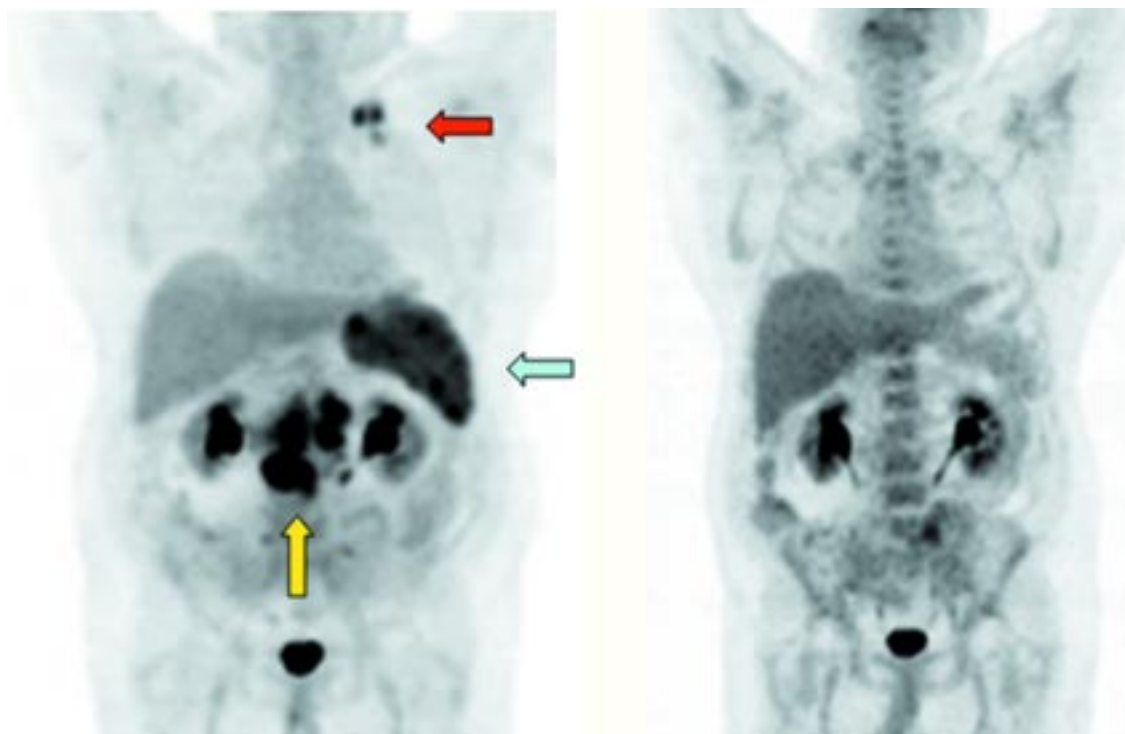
Images of pre- and post-therapy PET scans in a lymphoma patient treated with chemotherapy. The pretherapy image (left) shows increased FDG uptake in the left supraclavicular region (red arrow), mesentery, retroperitoneum (yellow arrow), and spleen (olive arrow). The post-therapy image (right) shows no residual disease, with a bone marrow activation commonly seen after chemotherapy and which can be seen with other treatments such as granulocyte colony-stimulating factor.
